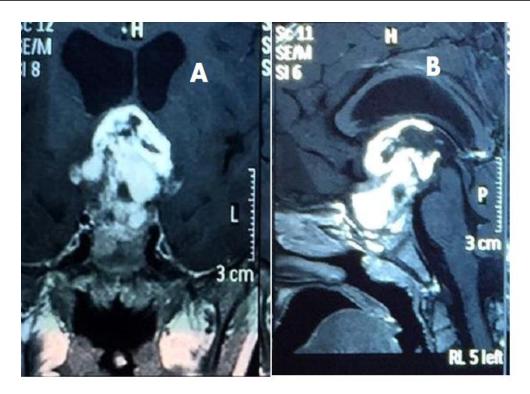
MAGNETIC RESONANCE IMAGING SHOWING INTRA- SUPRASELLAR HYPERINTENSE MASS LESION WITH DILATATION OF THIRD VENTRICLE.
